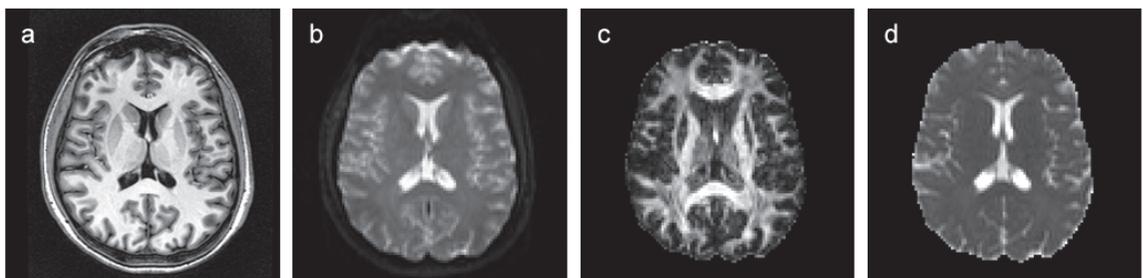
(a) T1-weighted axial slice of a healthy brain. (b) T2-weighted image. (c) Fractional Anisotropy map; gray matter presents almost no anisotropy, contrary to white matter. (d) Mean Diffusivity map; almost no contrast is visible between white and gray matter.
